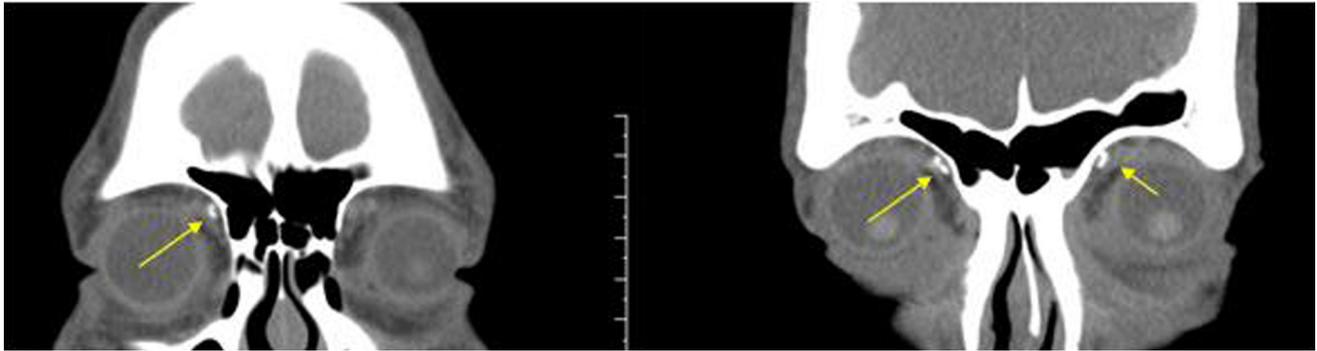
Coronal computed tomography scans show calcifications in the trochlear apparatus of the superior oblique muscle (arrows).
